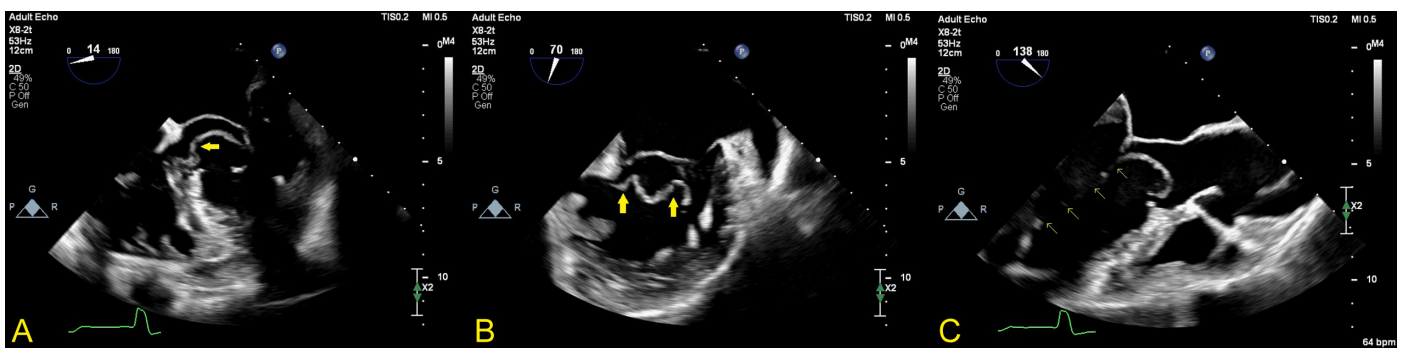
The transesophageal echocardiographic appearance of the accessory mitral valve (yellow arrows) in 0° 4-chamber (A) and bicommissural (B) views. The 135° long-axis view shows the accessory leaflet during systole and the course of its chordae from the tip of the leaflet to the ventricular wall (C) (4 thin yellow arrows).
